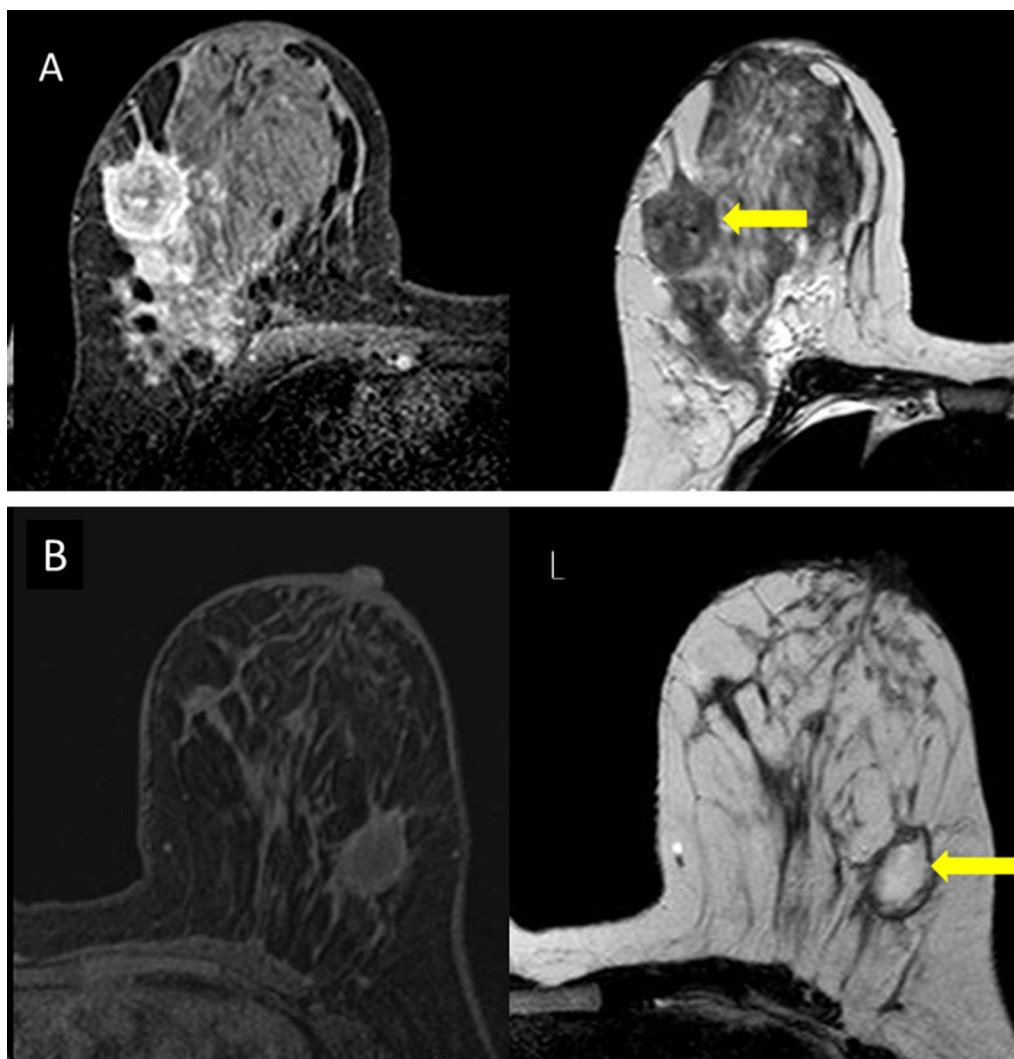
Two different cases showing rim-enhancing lesions. Case A: Axial T2-weighted MRI image shows corresponding low signal intensity (arrow) suggestive of malignant process. Pathology revealed invasive duct carcinoma. Case B: Axial T2-weighted MRI image shows corresponding bright signal intensity (arrow) suggestive of benign inflammatory process. Pathology revealed abscess cavity in a case of granulomatous mastitis
